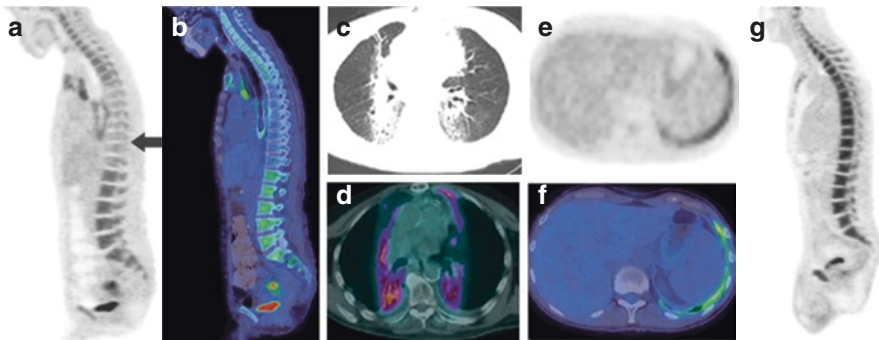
^{18}F -FDG PET/CT studies: (a, b) sagittal PET and fused PET/CT images show decreased tracer uptake in the thoracic vertebrae due to prior radiation therapy to this site [photopenia/decreased uptake in the bone is seen at the site of radiotherapy]; (c, d) transaxial CT and fused PET/CT images demonstrate increased uptake in para-mediastinal lung fibrosis after radiotherapy and should be read cautiously; (e, f) transaxial PET and fused PET/CT images demonstrate increased uptake in the left pleura with history of previous talc pleurodesis due to chronic granulomatous reaction [evaluation of mesothelioma is difficult following talc pleurodesis as the resulting increased pleural uptake can persist for several years]; (g) MIP image shows reactive diffuse tracer uptake in the bone marrow following chemotherapy in a lymphoma patient
